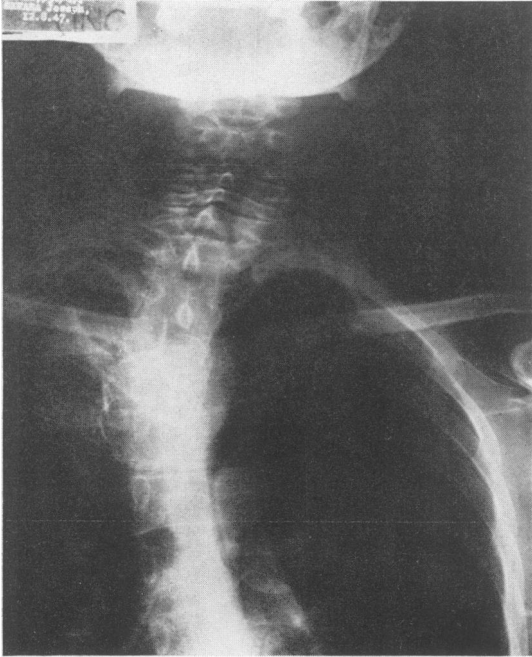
X-ray taken in 1947.
